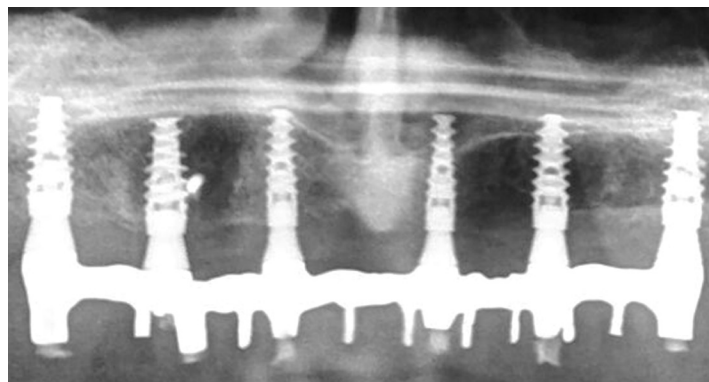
Panoramic radiograph at 3 years after loading of one of the patients with a severely atrophic maxilla randomly allocated to receive six to eight conventionally loaded implants after augmentation with bone substitutes (Dr. Pistilli, Rome).
